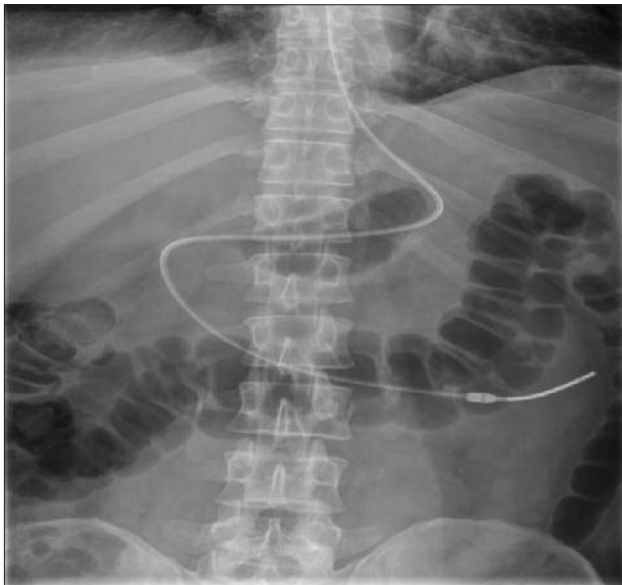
Plain film demonstrating good position of a nasojejunal feeding tube
